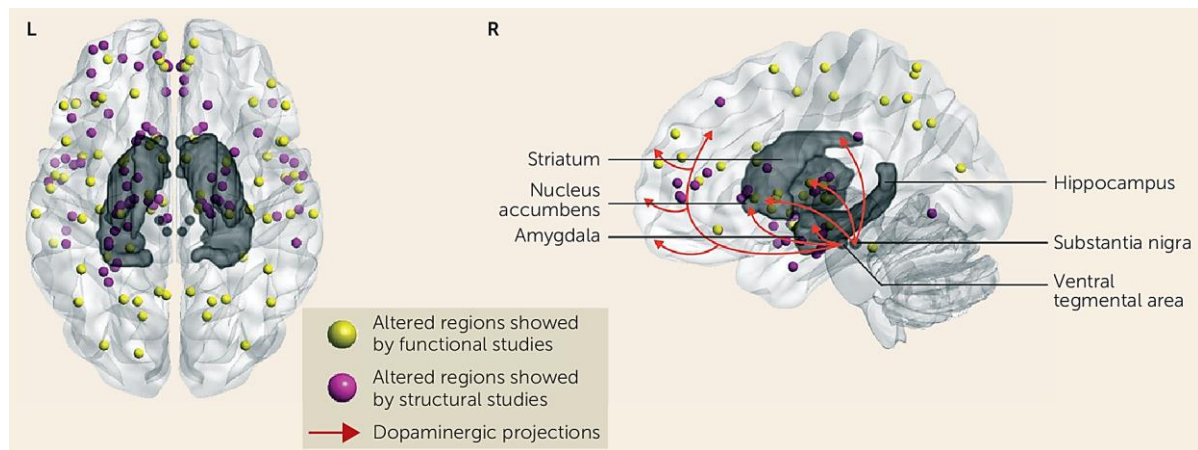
An image of the brain of a schizophrenic patient through MRI from both a horizontal view and a sagittal view [1].
